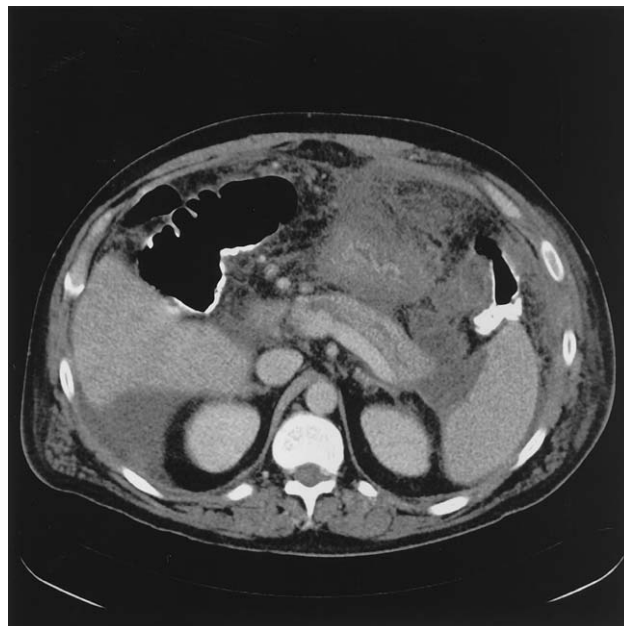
Contrast-enhanced abdominal computed tomography scan in a 47-year-old man with acute pancreatitis. Relevant findings include significant fat stranding of the peripancreatic tissue, with a fluid collection at the tail of the pancreas measuring approximately 4 cm × 4 cm. Pancreatic parenchyma enhances with intravenous contrast, with no evidence of pancreatic necrosis.
